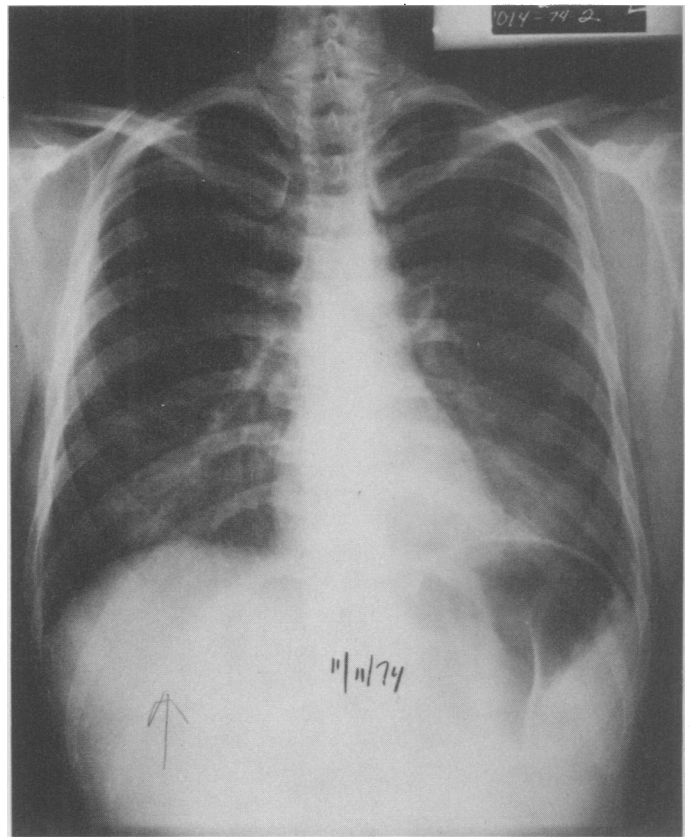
The predominant roentgenographic finding in early *Pneumocystis* pneumonia is a bilateral central infiltrate with sparing of the apices and bases. Profound hypoxia may be present with only minimal radiographic changes.
